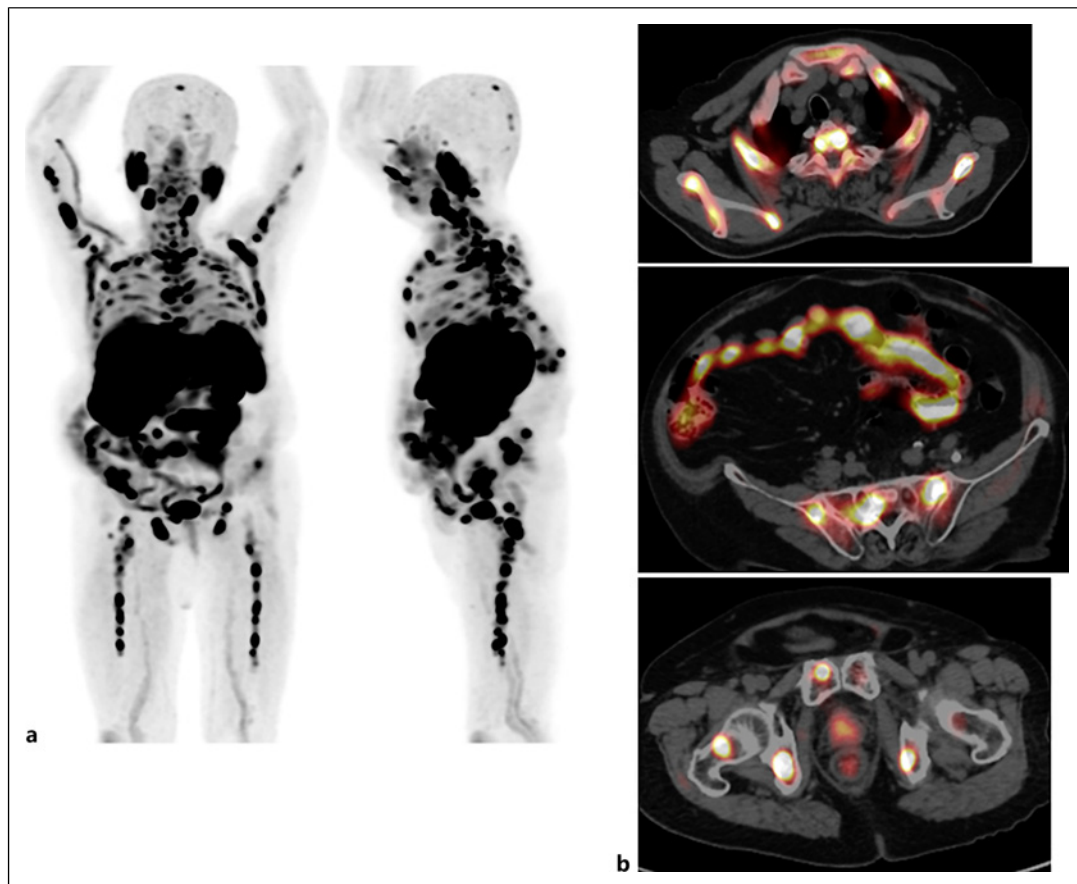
^{11}C -choline PET/CT at the time of bone marrow metastasis diagnosis. a Maximum intensity projection (MIP) ^{11}C -choline PET/CT showed diffuse bone marrow ^{11}C -choline uptake, confirming bone marrow metastasis. b Whole-body ^{11}C -choline PET/CT showed diffuse bone marrow ^{11}C -choline uptake, confirming bone marrow metastasis.
